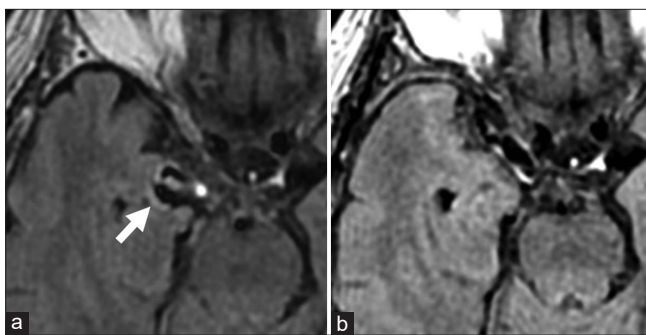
(a) The preoperative state fluid attenuated inversion recovery image in magnetic resonance imaging detected a substantial aneurysm located in the right posterior communicating artery, displaying high intensity in the brain parenchyma surrounding the aneurysm (arrow). (b) The fluid attenuated inversion recovery image of the magnetic resonance imaging scan taken 1 year postsurgery showed resolution of aneurysm-induced pressure drainage at the medial temporal lobe, and the high intensity surrounding the aneurysm had also disappeared.
